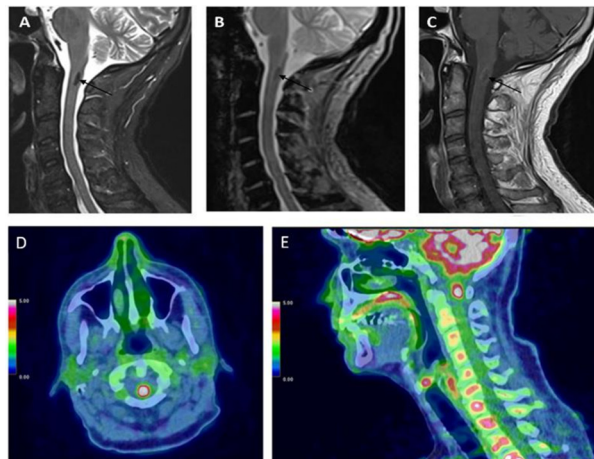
Sagittal cervical medullary MRI. STIR and T2*-weighted imaging sequences (A and B) reveal an intra-medullary lesion (C2) with hypointensity signal. T1-weighted imaging sequences with gadolinium (C) demonstrates intra-medullary enhancement (arrow). Fused FDG PET/CT axial (D) and sagittal (E) images showed intense and focal uptake within the spinal cord.
